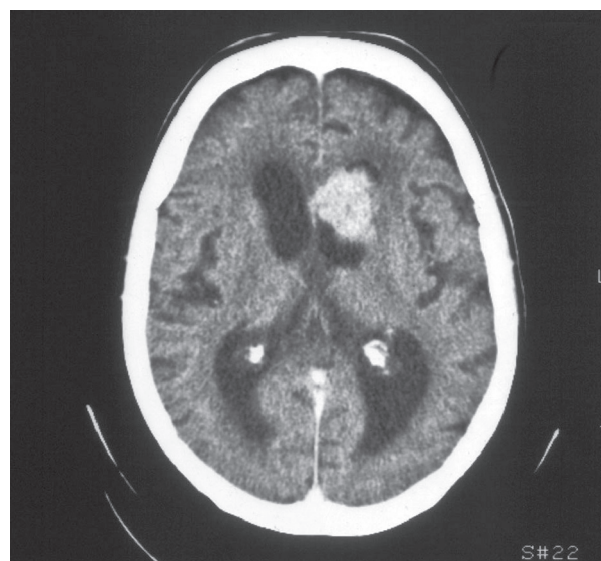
Preoperative computed tomography of the brain with contrast agent showing a homogeneously enhanced intraventricular lesion in the frontal horn of the left lateral ventricle with subsequent unilateral hydrocephalus.
